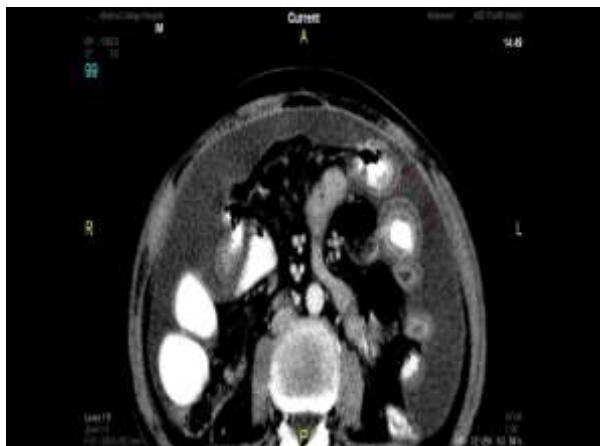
CT showed stratified pattern of attenuation due to submucosal edema at splenic flexure (arrows) in acute bowel ischemia, associated with ascites and mesenteric edema.
